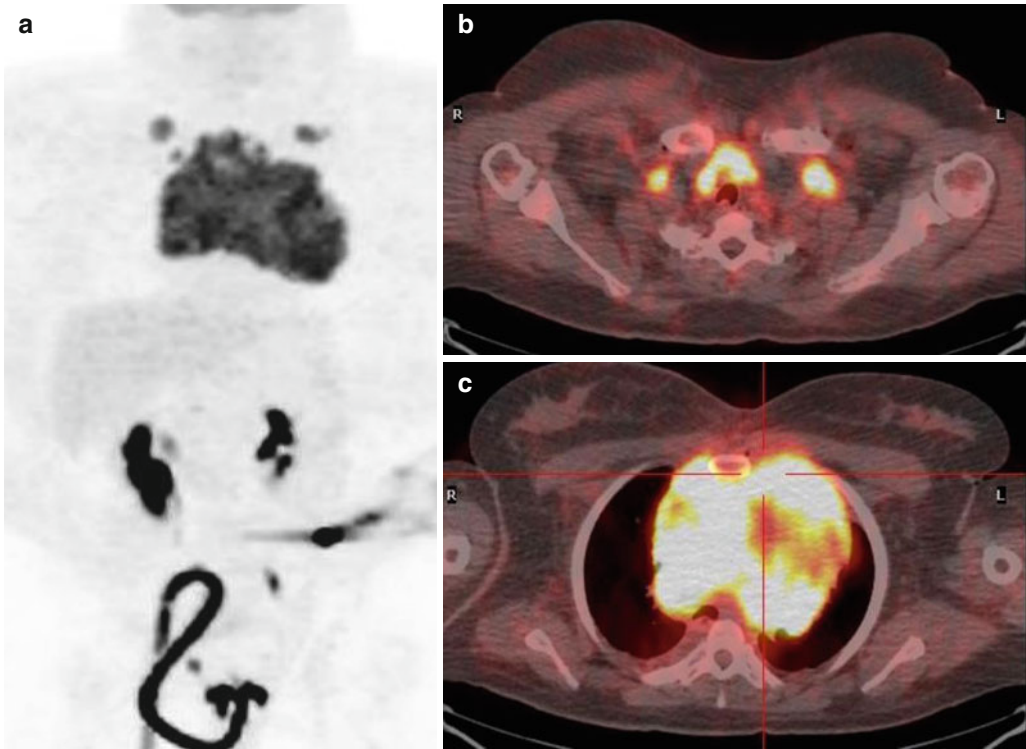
(a–c) MIP-PET and fused PET/CT- initial staging: highly abnormal 18FDG uptake at a mediastinal mass and supraclavicular lymph nodes bilaterally
